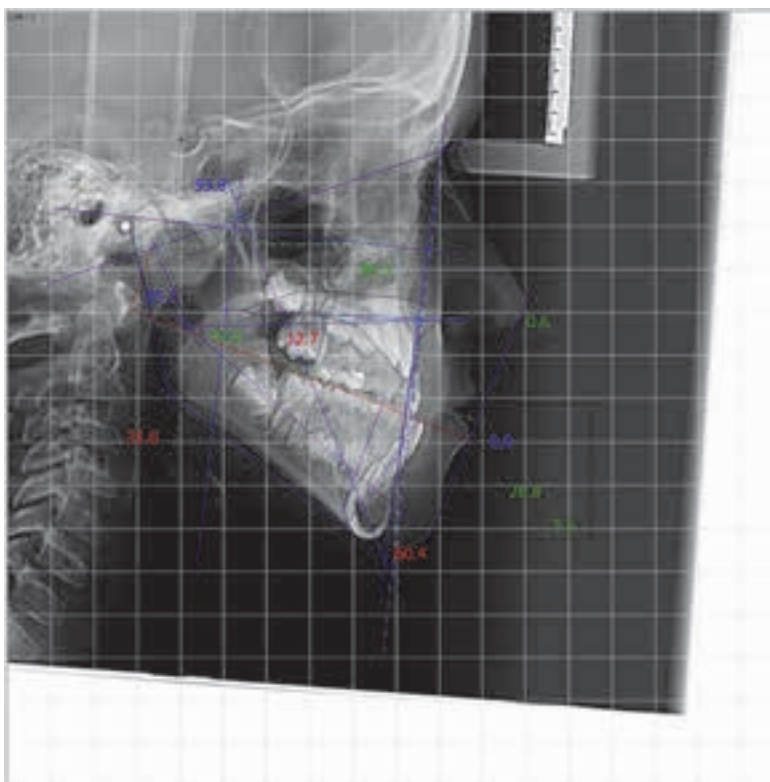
Patient's cephalometric X-ray.
